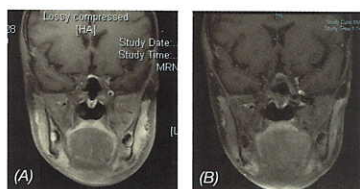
MRI scan (A) showed enhancement of the left infraorbital (*), trigeminal nerve, trigeminal ganglion and infratemporal region. A post-surgery MRI scan (B) 3 months later did not reveal any recurrence.
